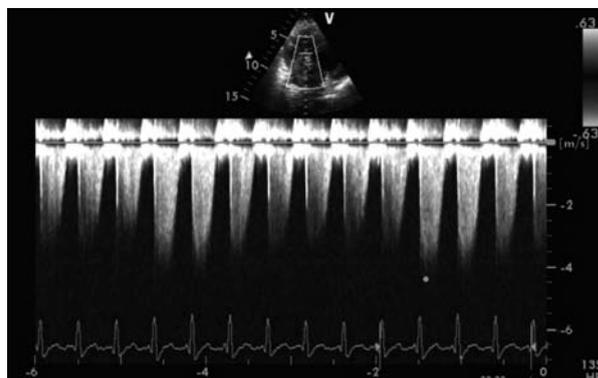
Transthoracic echocardiogram showing high velocity of tricuspid valve regurgitation indicating severe pulmonary artery hypertension.
